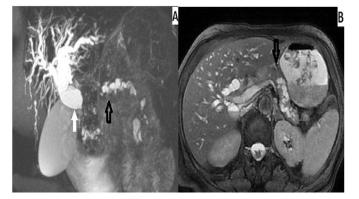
MRI in pancreatic cancer. A. MRCP: the tumor causes dilatation of the pancreatic duct (black arrow) and extrahepatic bile duct (white arrow), also known as double duct sign. B. T2 FIESTA with fat saturation: hypointence mass in pancreatic body.
